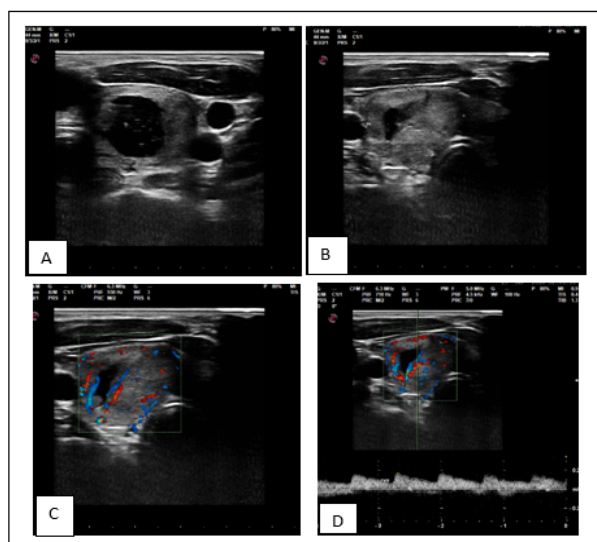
ATA Thyroid Nodule Sonographic Pattern - Low Suspicious for Malignancy. FNAC diagnosis - Adenomatous nodule - Bethesda II.
